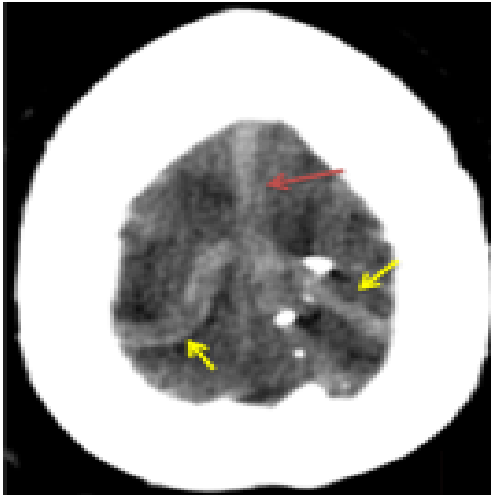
Cerebral CT before injection of PDC showing the superior longitudinal sinus is spontaneously dense (red arrow), as well as parietal cortical veins bilaterally (yellow arrow)
